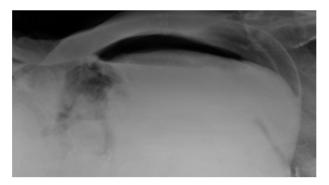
Cross-table lateral abdominal radiograph showing the presence of pneumoperitoneum.
